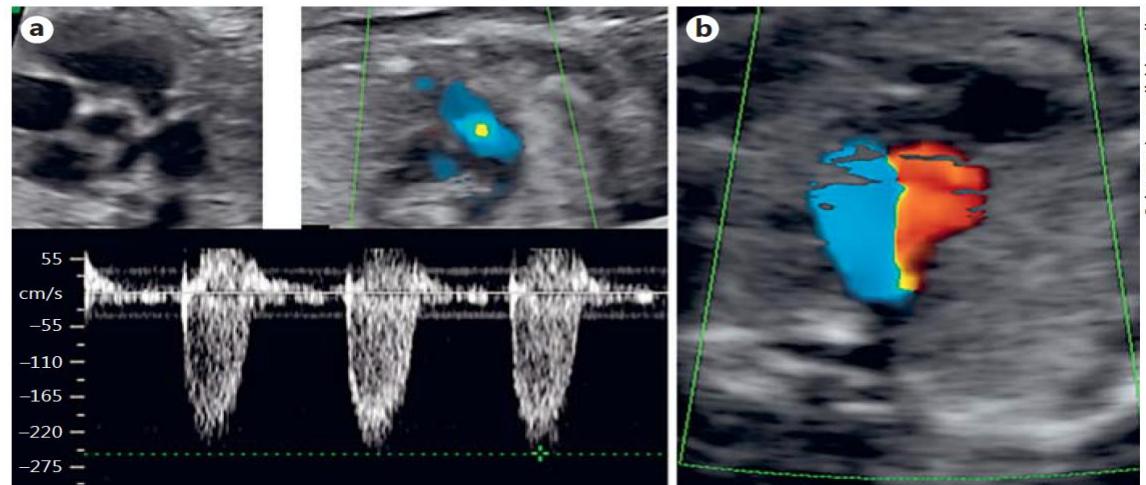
Echocardiographic diagnostic criteria. a PS (thickened or narrow pulmonary valve, turbulent flow, peak systolic velocity >120 cm/s). b PA (no forward flow across the pulmonary valve, reverse flow in the ductus arteriosus).
